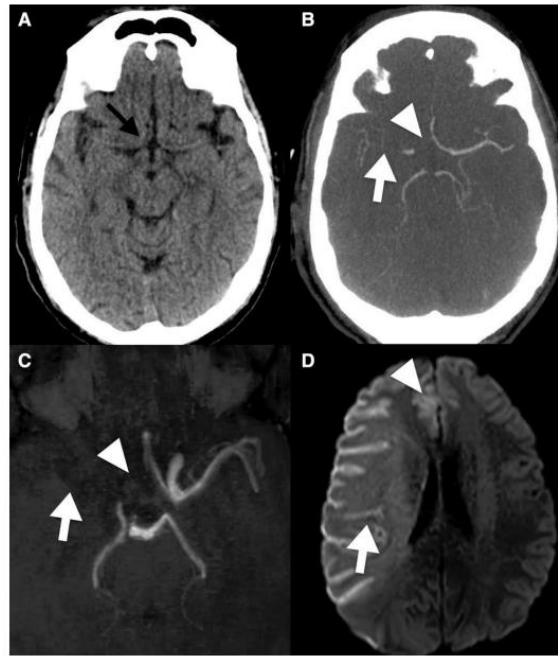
Early brain imaging findings in coronavirus disease 2019 (COVID-19) patients with large vessel occlusion strokes. A 56-year-old man with left hemiplegia (A and B), the computed tomography (CT) was performed 0.5 h after onset. The noncontrast-CT (A) showed no early ischemic changes (black arrow shows the anterior cerebral artery). The CT-angiography (B) shows a proximal middle cerebral artery (MCA) occlusion (arrow) associated with a proximal anterior cerebral artery occlusion (arrow head), the clot burden was 5. A 45-year-old female with left hemiplegia (C and D), the magnetic resonance imaging (MRI) was performed 2.25 h after onset. The 3-dimensional time-of-flight (C) shows a carotid terminus occlusion with proximal MCA occlusion (arrow) associated with an anterior cerebral artery occlusion (arrow head), the clot burden was 5. The DWI sequence (D) shows ischemic lesions in both MCA and anterior cerebral artery territories (arrow and arrow head, respectively), DWI-ASPECTS (Diffusion-Weighted Imaging–Alberta Stroke Program Early Computed Tomography Scores) was 0, infarct core volume was 186.5 mL.
